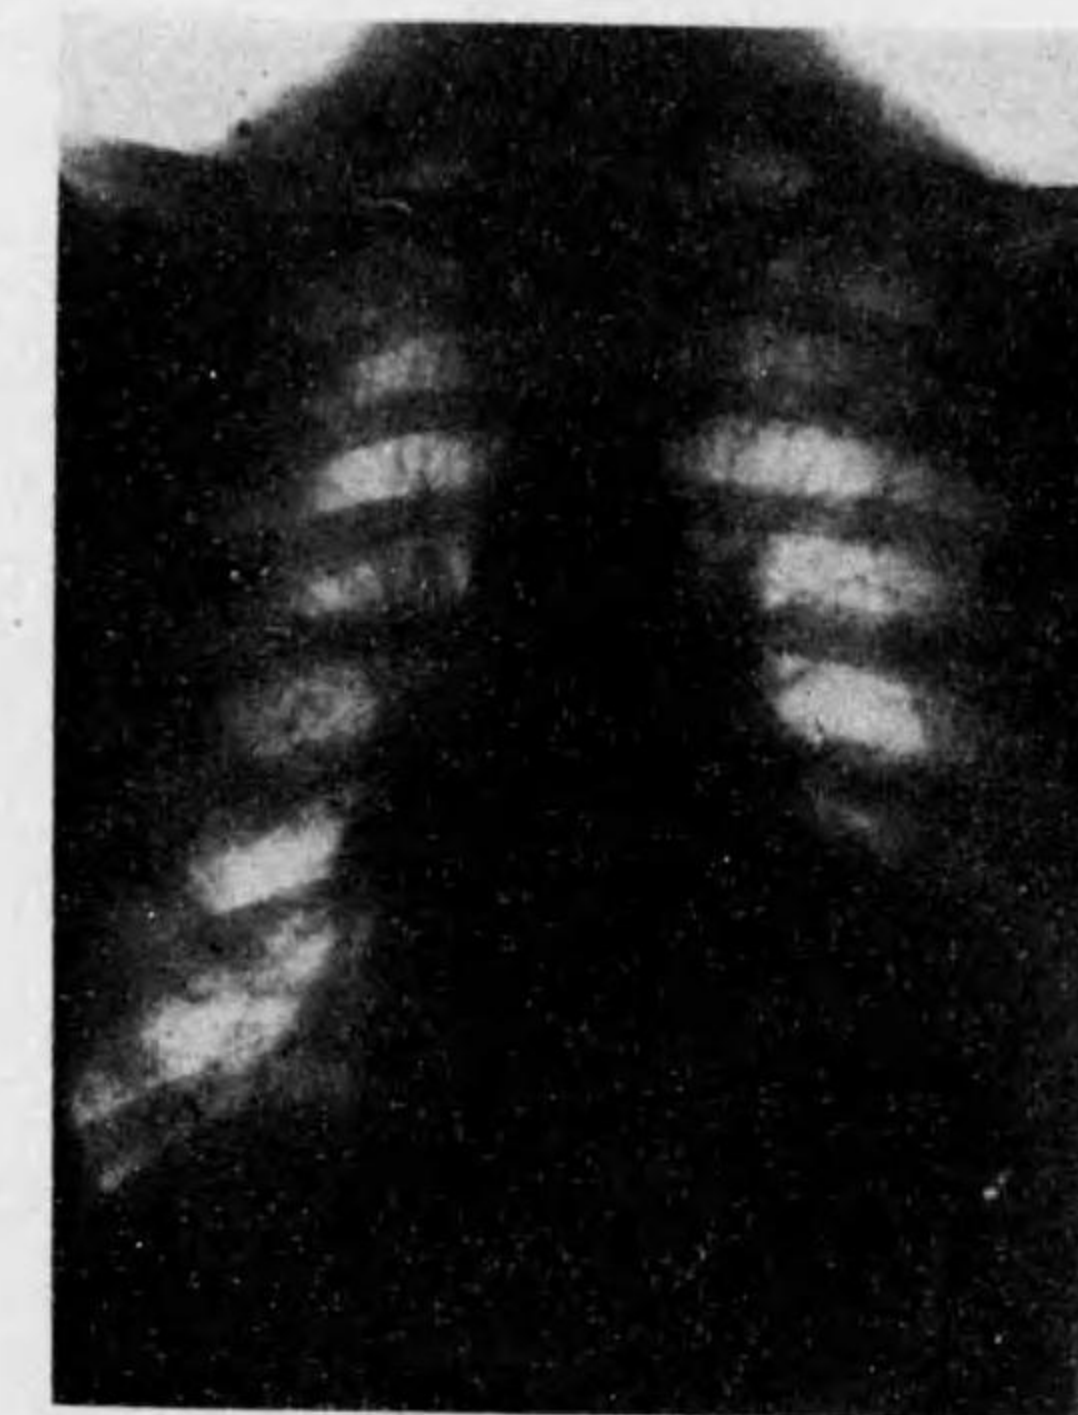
Case XXXIV. Patient, alcoholic, aged 58, began with subacute cough and expectoration, which was later followed by dyspnea and fever. X-ray taken in erect position, 7/3/24.
